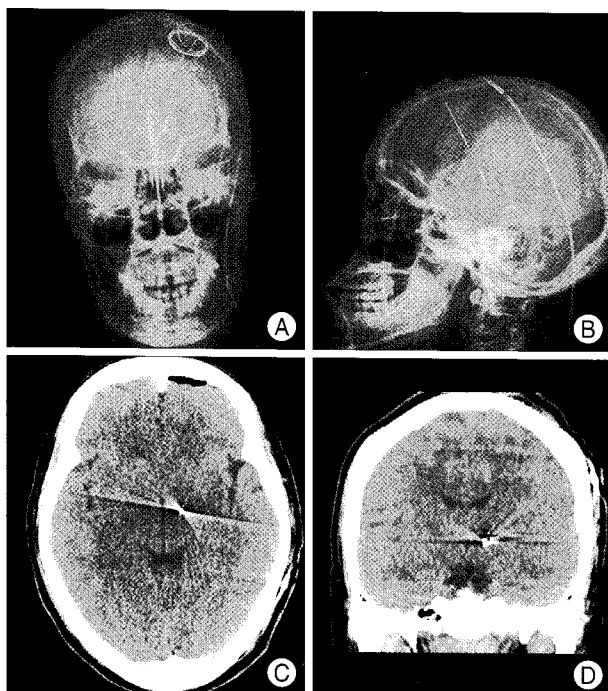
Post-operative (A and B) simple radiographs and (C and D) computed tomography scans demonstrate proper location of lead.
